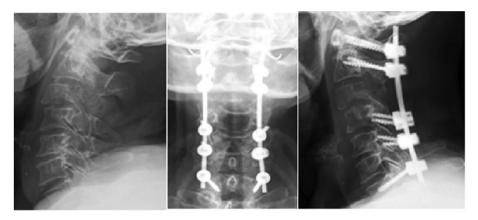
Radiographic study of a 69-year-old woman (patient #30). (A) Plain radiograph lateral view of the cervical spine demonstrates spinal metastasis at the posterior part of the body, and at posterior elements of the C4 vertebra with anterior listhesis of C3 over C4. (B, C) Postoperative anteroposterior and lateral radiographs show decompressive laminectomy from partial C2 to C5 with cervical stabilization using lateral mass screw and pedicle screw systems.
